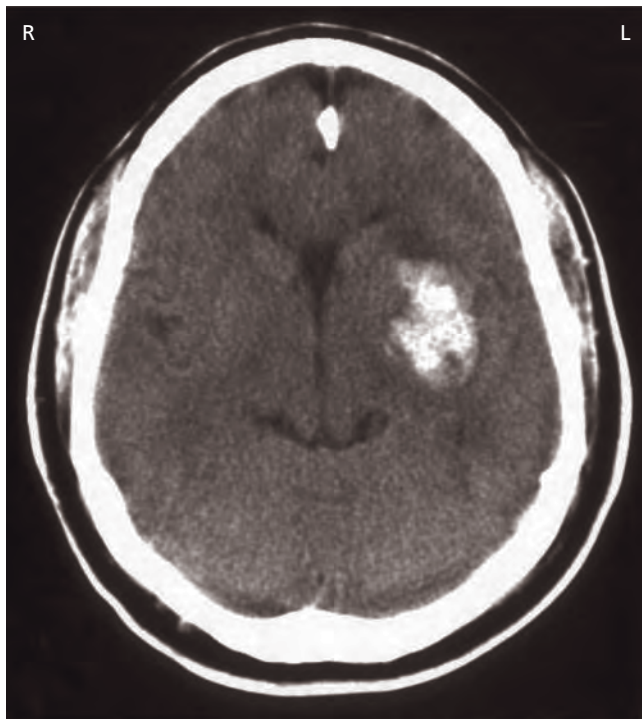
Large putaminal haematoma (unenhanced CT).
